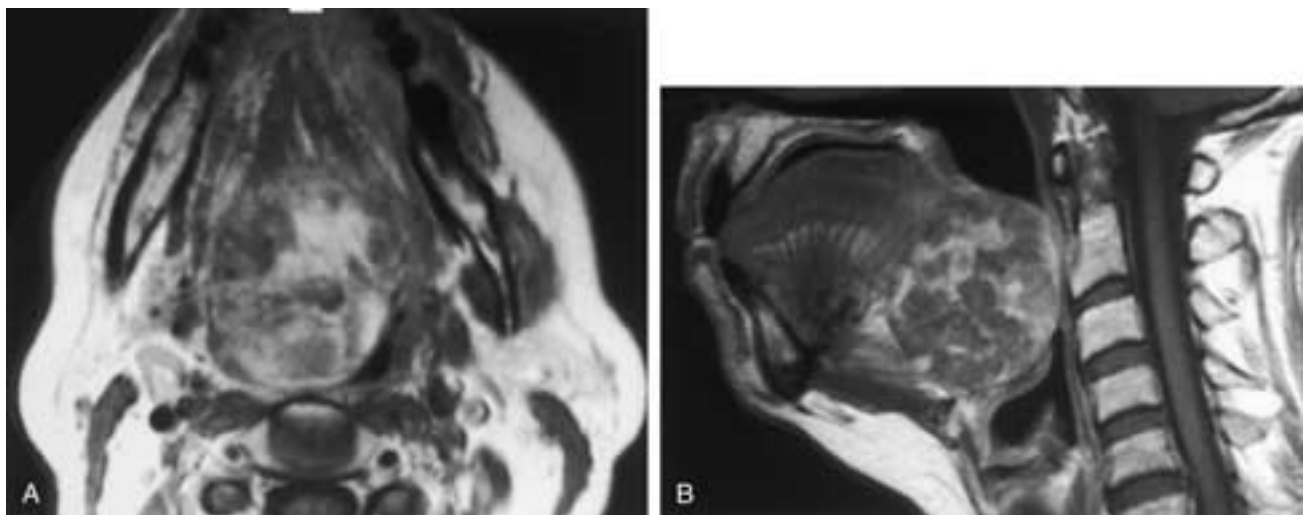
Lingual thyroid with goiter. A and B, Axial and midsagittal T1-weighted MR images following contrast administration reveal markedly heterogeneous enhancement of this multinodular goiter affecting lingual thyroid tissue. Note the severe compromise of the oropharyngeal airway on both images. (Courtesy of Dr. Jan Casselman.)
